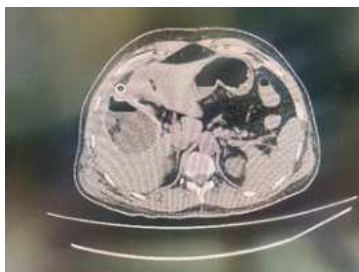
4B and 4C: showing post-operative CT where the cyst stroma and daughter cysts being replaced by the omentum placed inside it during surgery in axial, coronal and sagittal view respectively.
